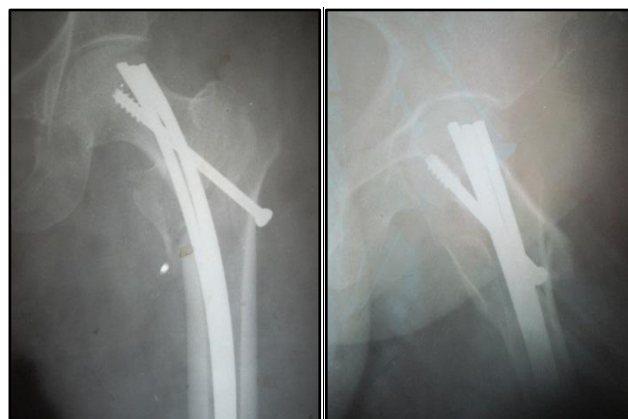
Post-Operative Radiograph (Antero-Posterior View & Lateral View)
